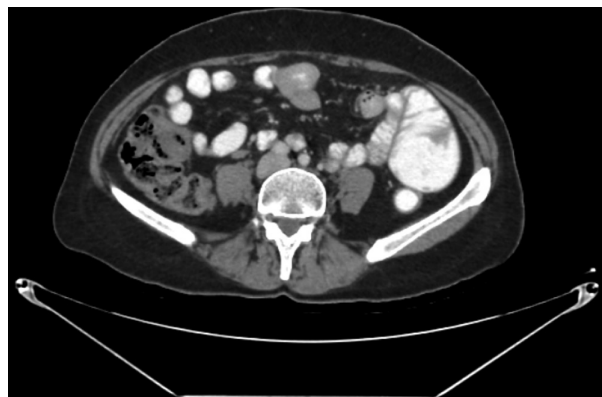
CT scan of a small bowel tumor
